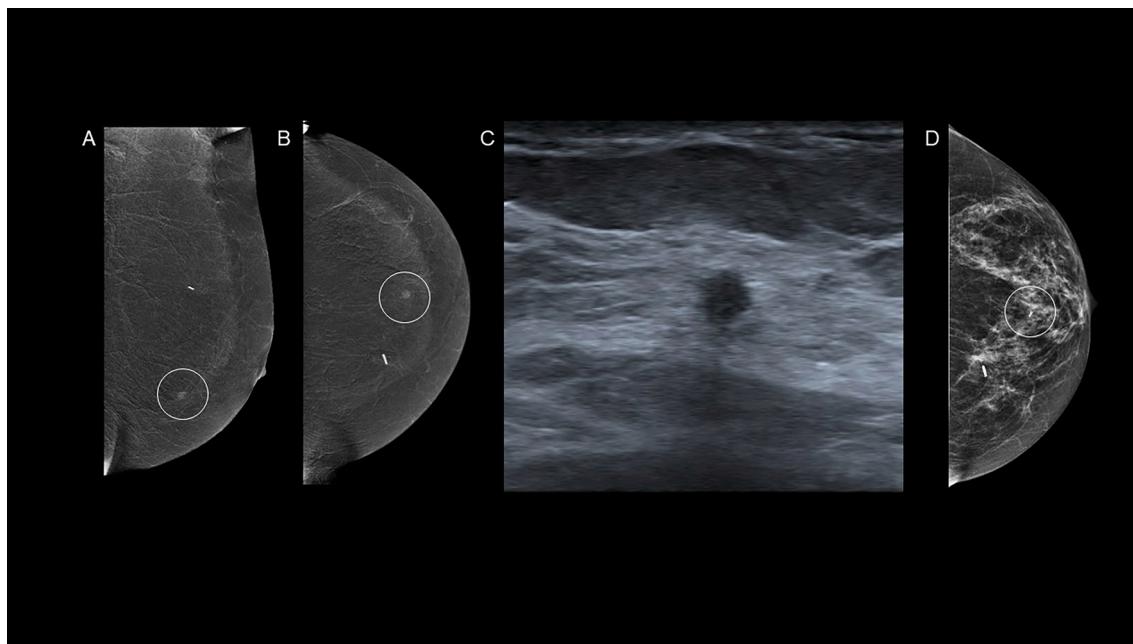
57-year-old with history of left breast lobular carcinoma in situ. Recombined left mediolateral oblique (A) and craniocaudal (B) views show a 0.4 cm enhancing mass in the lower central breast. Targeted ultrasound (C) shows a corresponding 0.4 cm irregular mass in the 6:00 axis. Ultrasound-guided biopsy yielded invasive lobular carcinoma. Biopsy marker corresponds to site of enhancement on the post-biopsy mammogram (D).
